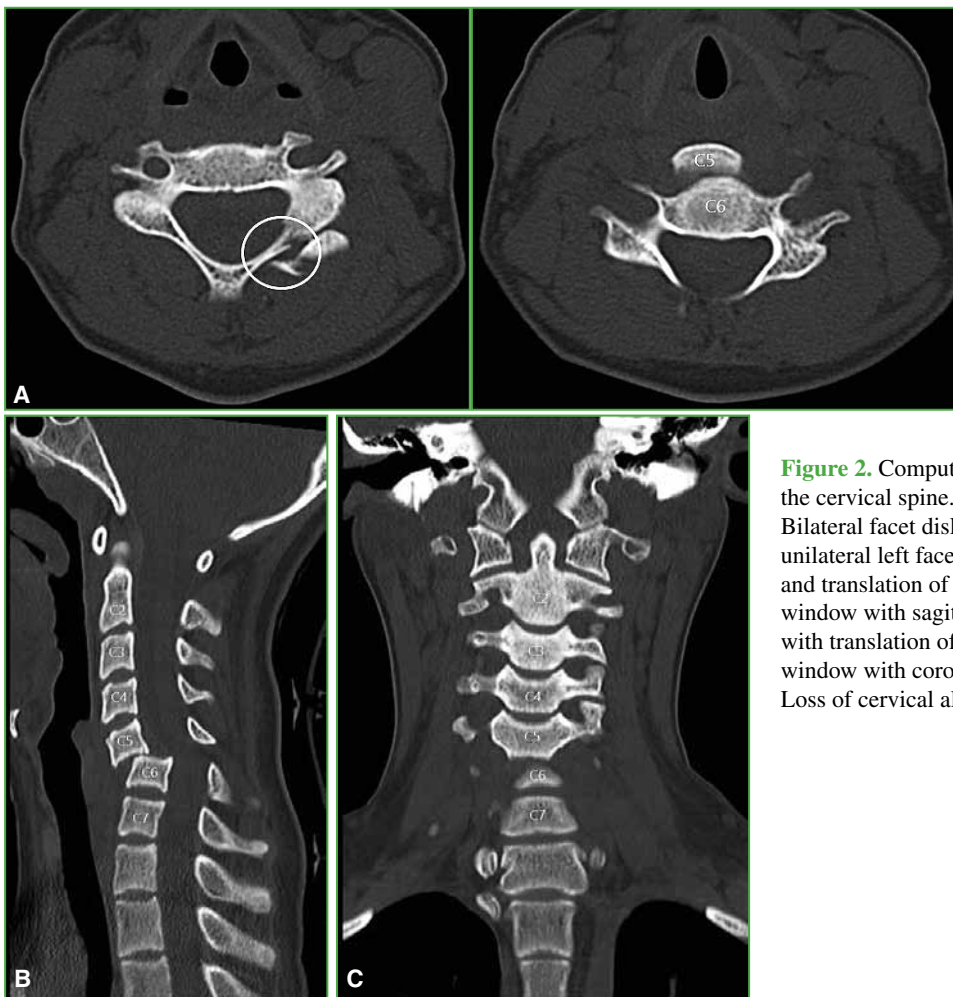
Computed tomography of the cervical spine. A. Axial planes. Bilateral facet dislocation with unilateral left facet fracture (circle) and translation of C5-C6. B. Bone window with sagittal reconstruction with translation of C5-C6. C. Bone window with coronal reconstruction. Loss of cervical alignment.
